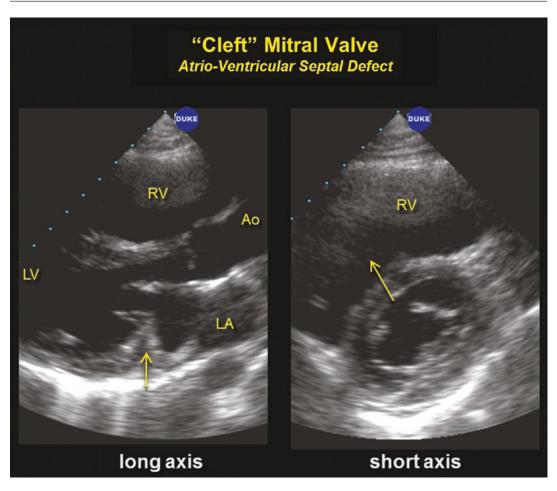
Parasternal long axis from a patient with an AV Canal defect (atrio-ventricular septal defect) with mal-alignment of the mitral and aortic valves (left panel).
